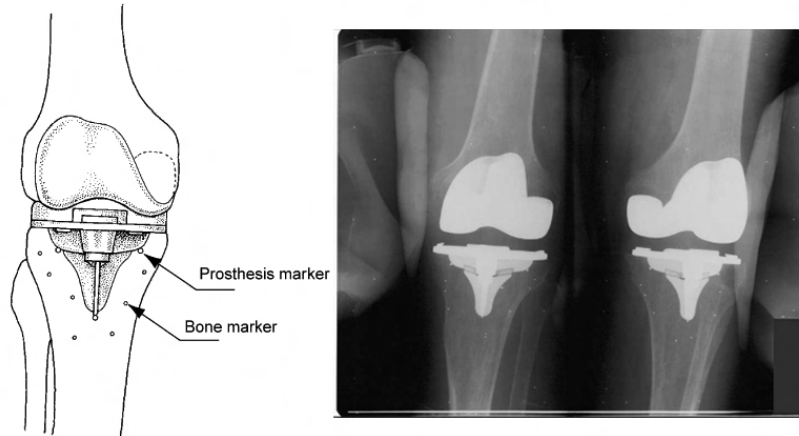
RSA of a prosthetic knee: a) markers positioning b) the corresponding X-ray image. Image from [VNRR02] used by permission.
